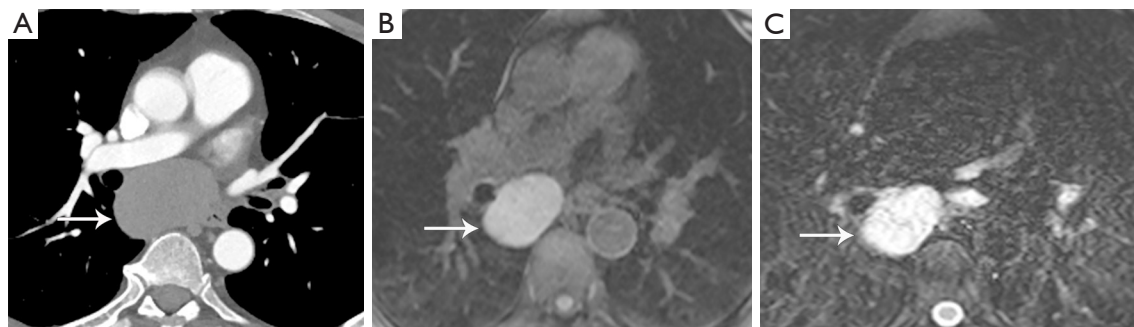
Esophageal duplication cyst. (A) Contrast enhanced CT shows lesion (arrow) in the right subcarinal region with heterogeneous attenuation and could be cystic or solid. When CT is indeterminate, MRI is useful to differentiate fluid from solid mediastinal lesions. (B,C) MRI images show the visceral mediastinal lesion (arrow) with intermediate signal intensity on T1-weighted (B) and high signal intensity on T2-weighted (C) MRI images. The intermediate signal intensity on T1-weighted images can be seen with cysts with proteinaceous material. CT, computed tomography; MRI, magnetic resonance imaging.
